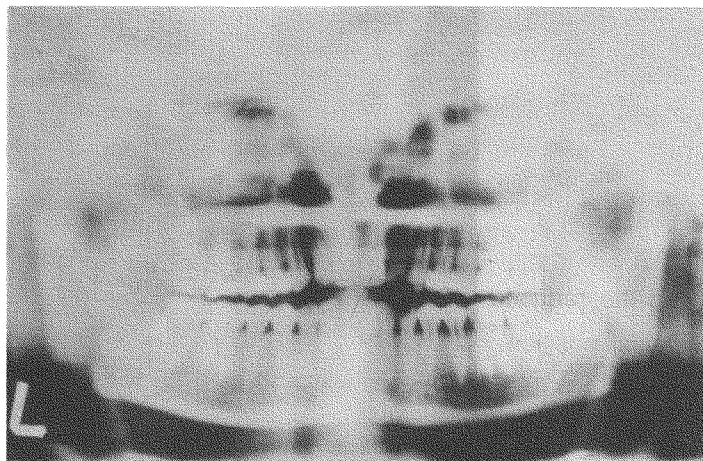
Pre-operative x-ray show bilateral fracture dislocation of condyles (condylar neck level). Note the condylar heads position are not in the sockets.
